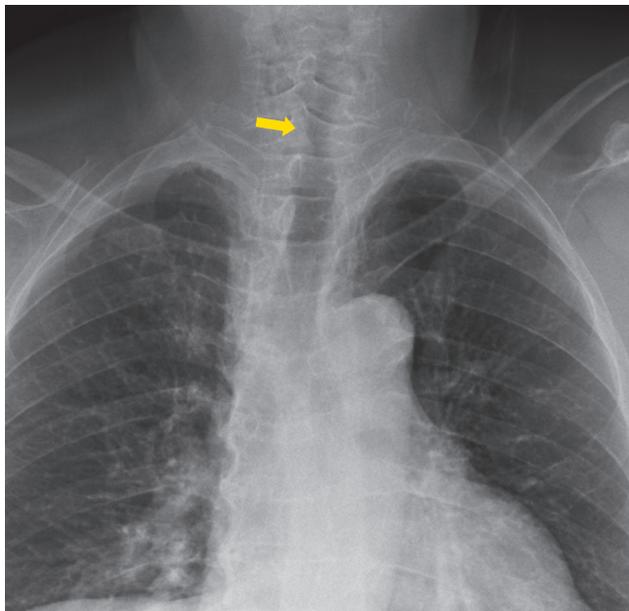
Posteroanterior chest radiograph revealing a tracheal stricture (arrow)
